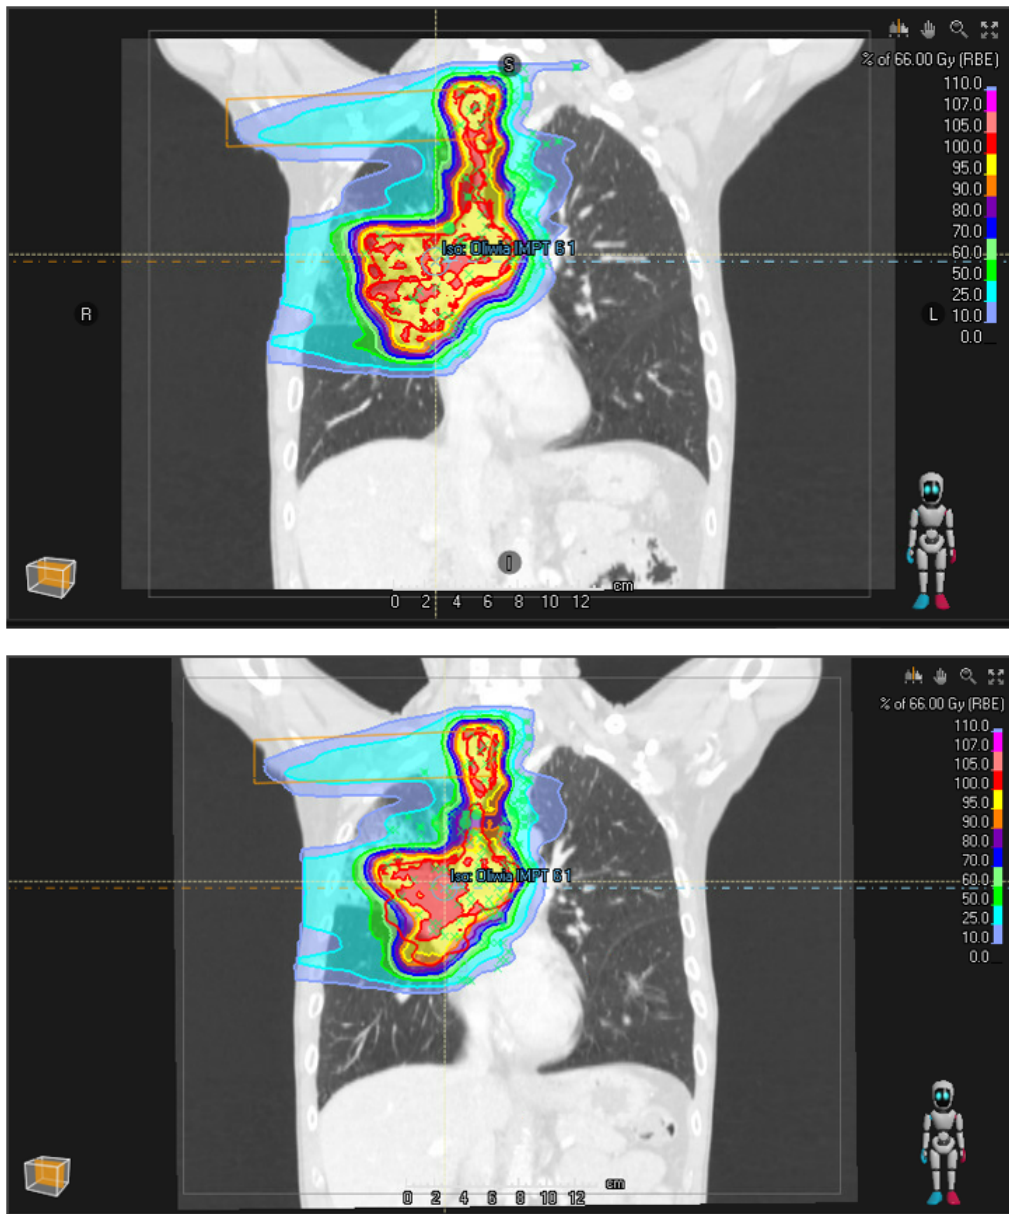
Dose distribution using IMPT technique for patient 6, based on the planning CT (above) and recalculated on the control CT (below). The red solid line shows the ICTVu.
